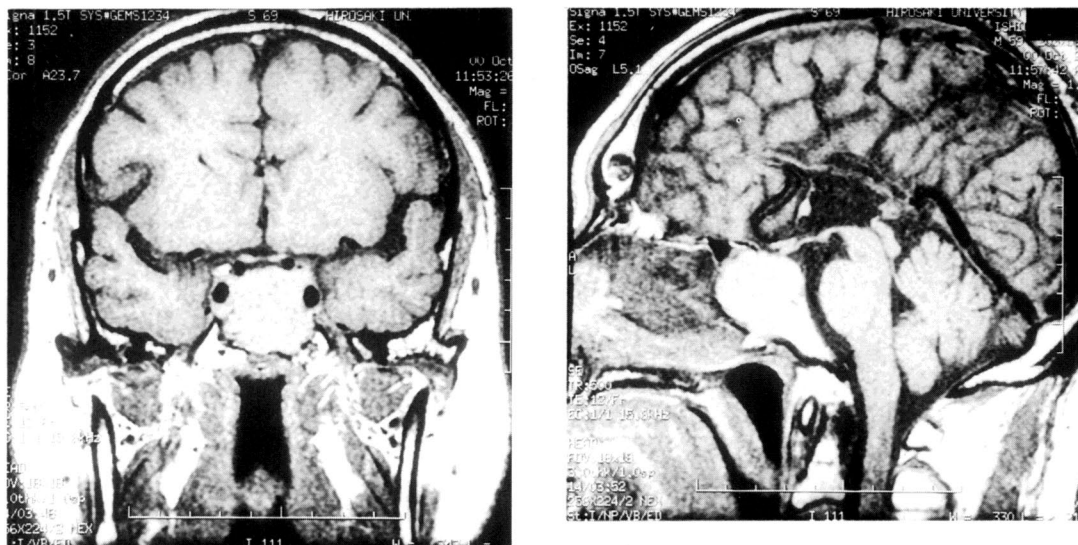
Magnetic resonance imaging of the head. Coronal and sagittal T1-weighted images enhanced with gadolinium diethylenetriamine penta-acetic acid demonstrate the presence of macroadenoma in the pituitary.
